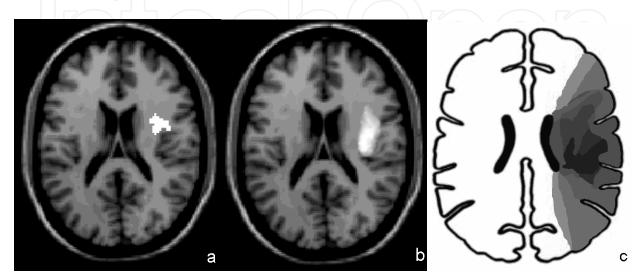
Lesion pattern in severe MCA stroke. a) Area of the maximal PWI deficit in severely as compared to slightly affected patients. b) Area of common DWI-changes before acute stroke therapy (n=64). c) Overlap of the residual infarct lesions in hemispheric white matter (n=13). Adapted from (Seitz *et al.*, 2009; Stoeckel *et al.*, 2007).
